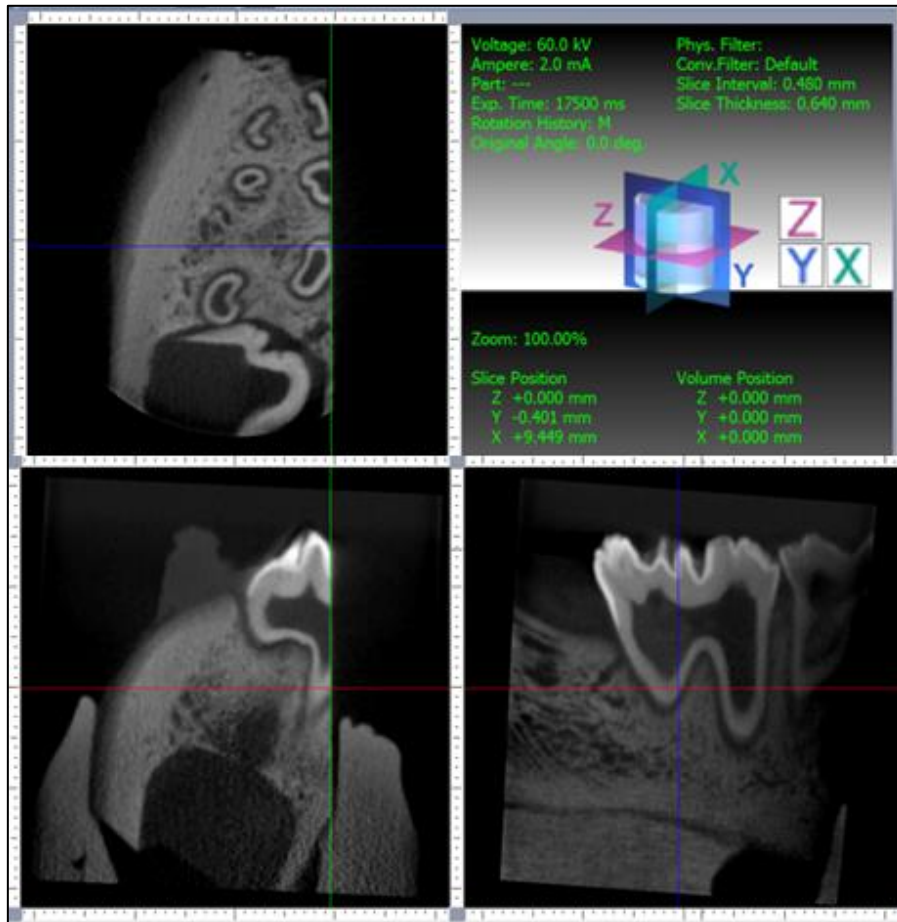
The CBCT software One-Data viewer which was used by the observers to take the measurements. The measurements were taken on the lower right image (mesio-distal longitudinal section). Notice the green sagittal line was placed at the edge of the sectioned surface of the sample on the upper and lower left images.
